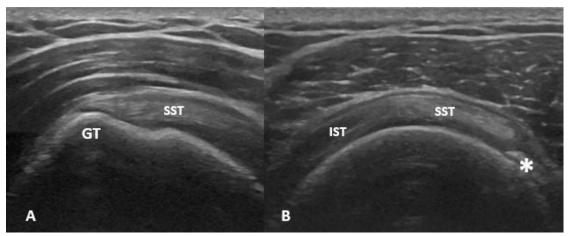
Normal diagnostic ultrasonography of the rotator cuff. A- Longitudinal view which compares to the coronal magnetic resonance imaging (MRI) perspective. B- Transverse view which compares to the sagittal MRI perspective.
